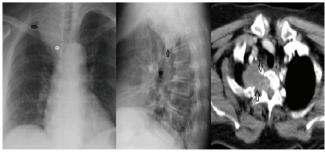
Posteroanterior chest X-ray, lateral X-ray and computed tomography (CT) image of schwannoma
